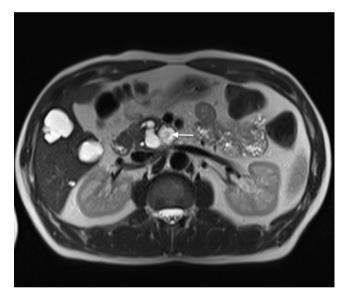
T2-weighted axial scan demonstrating the worrisome 7-mm diameter mural nodule inside the main BD-IPMN located at the uncinate process.
